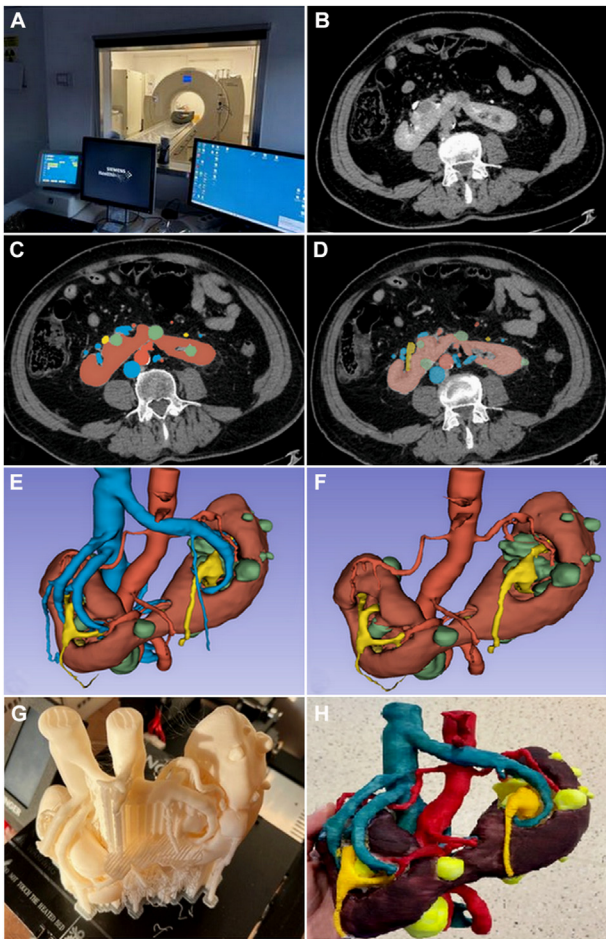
General overview of a three-dimensional printing workflow. (A and B) Image acquisition—high resolution volumetric dataset including CT, MRI, or ultrasound; (C and D) Image segmentation to create individual object for anatomy of interest; (E and F) Computer-aided design model to prepare for printing, create digital models, and smooth and verify objects to ensure anatomical accuracy; (G and H) A three-dimensional printing to print model using desired materials and remove support material.
